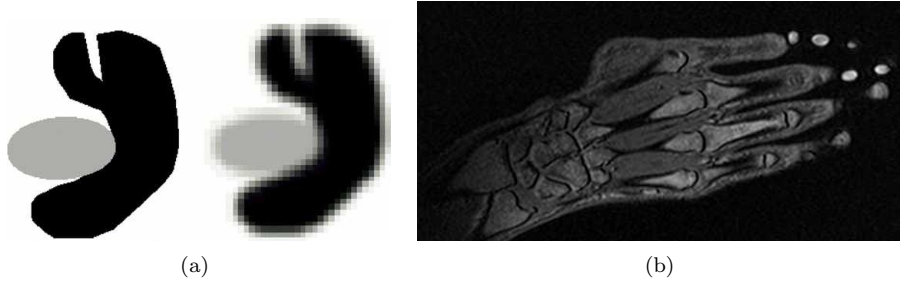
Examples for the partial volume effect: (a) Synthetic image - the second image is corrupted by the PVE, resulting in difficulties for the accurate boundary extraction between regions. [51], (b) A real MR image of a hand, affected by PVE - in some regions of the image it cannot be decided the boundary between the bone and the surrounding tissue
